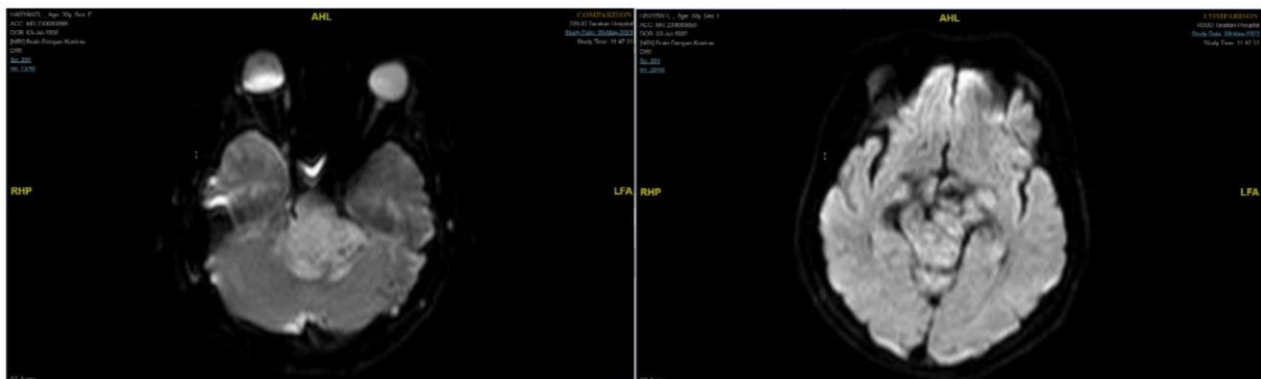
Magnetic resonance imaging results taken on May 9, 2023.
